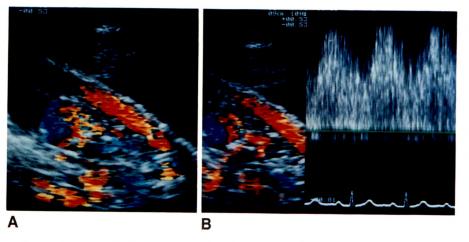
Color flow Doppler images show a mosaic pattern with red shades and blue regions in right adnexal mass (A). Pulsed Doppler sonography shows rapid and turbulent systolic blood flow with relatively high-velocity diastolic component (B).
